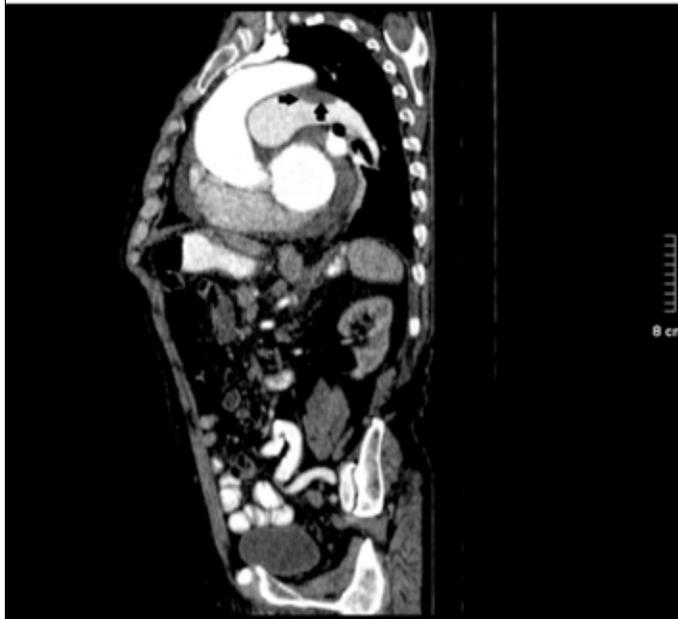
A-B. Multislice CT demonstrated main pulmonary artery of 6.1 cm, left pulmonary artery of 3.3 cm and right pulmonary artery of 3.6 cm. There was a massive (1.3 cm) thrombus in the lumen of the aneurysmatic left pulmonary artery
